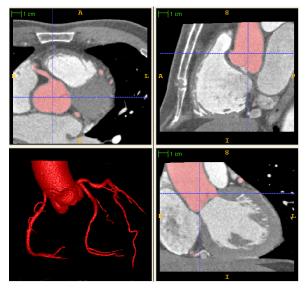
A CTA data set in axial, coronal and saggittal views and the 3D view of the segmented coronary arterial tree.
